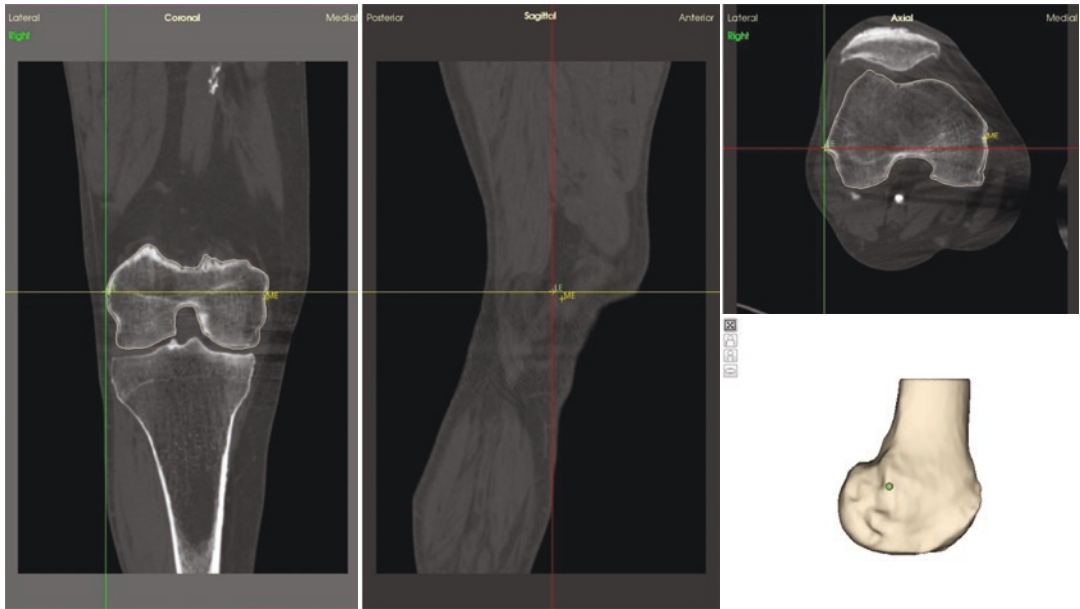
CT slices of a patient's knee and the most lateral point of the lateral femoral epicondyle selected
